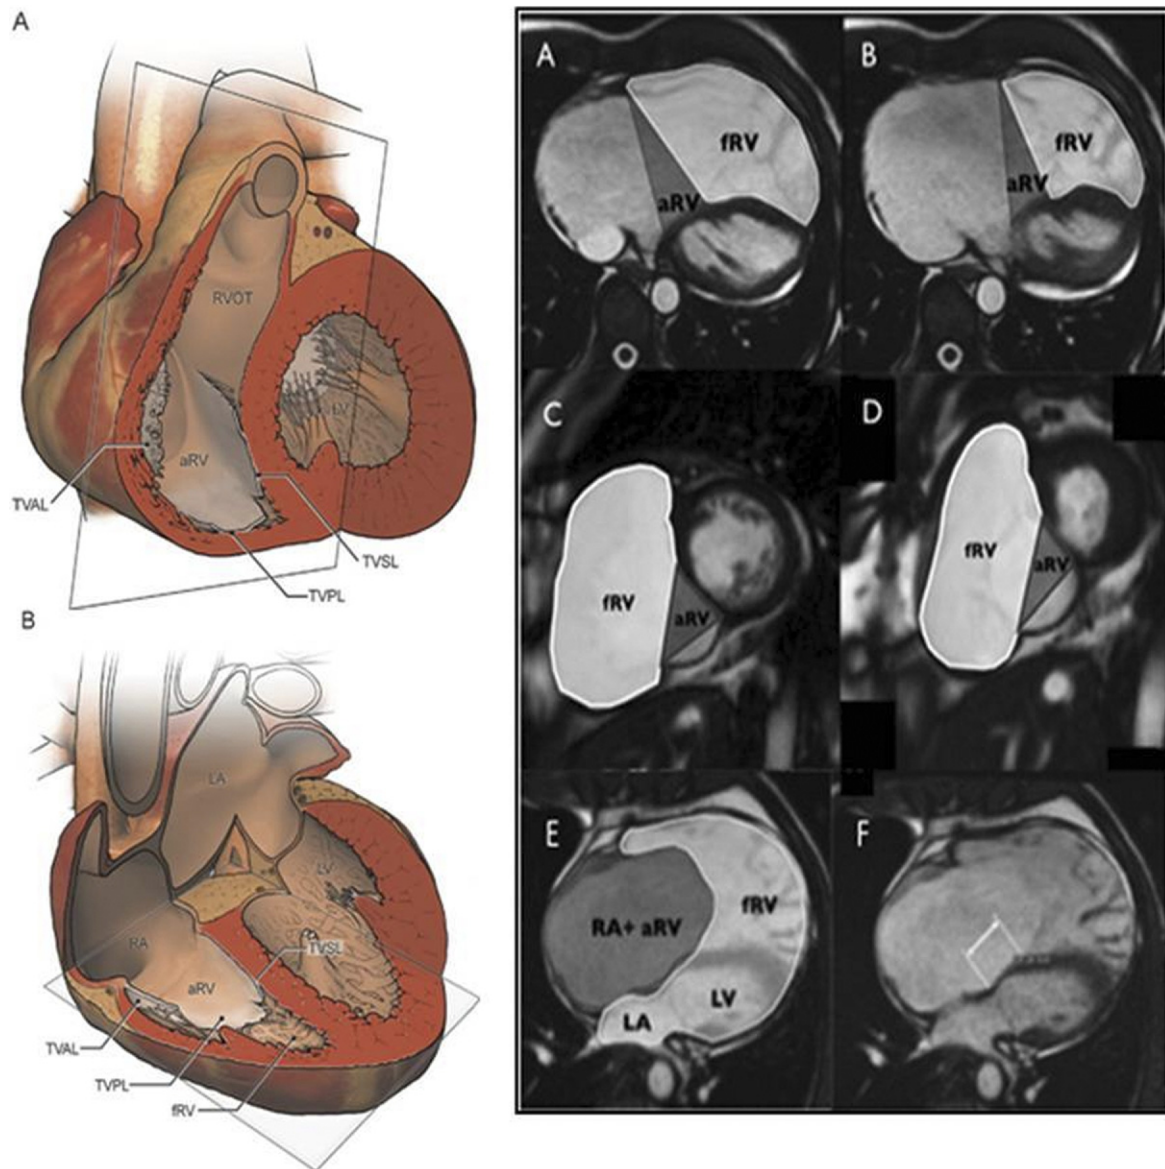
Left: Three-dimensional reproduction of heart with Ebstein malformation demonstrating: views of tricuspid valve from (A) short axis and (B) axial imaging. Right: Cardiac MRI showing systolic and diastolic contours of functional RV and atrialized portion of RV in (A,B) axial and (C,D) short-axis views. (E) Severity index representing ratio of areas of right atrium and atrialized RV in numerator and summation of functional RV and left atrium and left ventricular areas in denominator (ie, severity index = [right atrial area + atrialized right ventricular area]/[functional right ventricular area + left atrial area + left ventricular area]). (F) Degree of apical displacement of septal leaflet of tricuspid valve (in millimeters) measured in ventricular diastole. aRV, atrialized right ventricle. fRV, functional right ventricle; LA, left atrium; LV, left ventricle; RA, right atrium; TVAL, tricuspid valve anterior leaflet; TVPL, tricuspid valve posterior leaflet; TVSL, tricuspid valve septal leaflet. (Reprinted with permission.)
